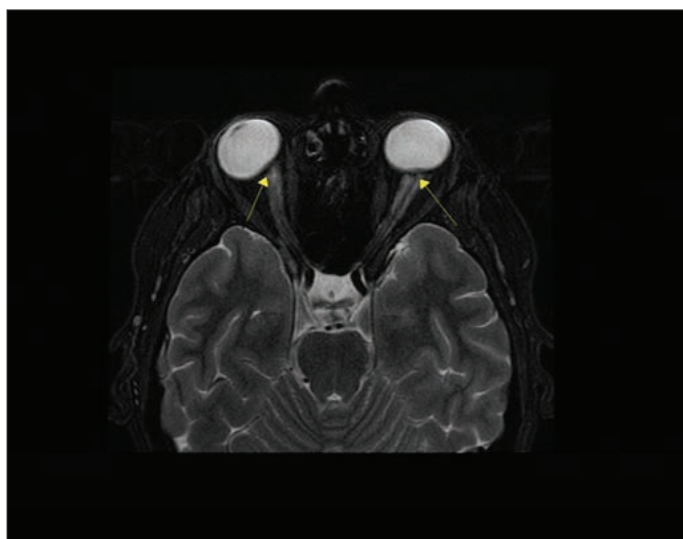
Preoperative brain MRI (T2-weighted sequence, axial plane). Notice the applanation of the back side of bulbi and slightly widened sheets of optic nerves (arrows).
